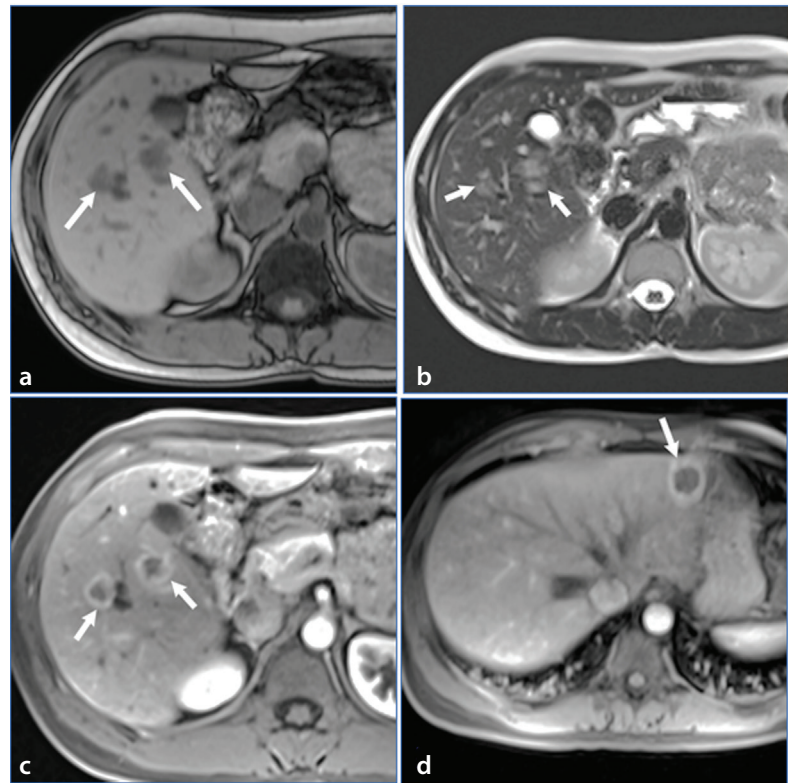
Epithelioid hemangioendothelioma, multiple. Axial T1-weighted (a) and axial T2-weighted (b) images and axial post-gadolinium T1-weighted images with fat suppression (c, d) show multiple liver lesions (arrows). The lesions demonstrate slightly high T2 signal intensity, low T1 signal intensity, and ring-like enhancement following contrast administration.
